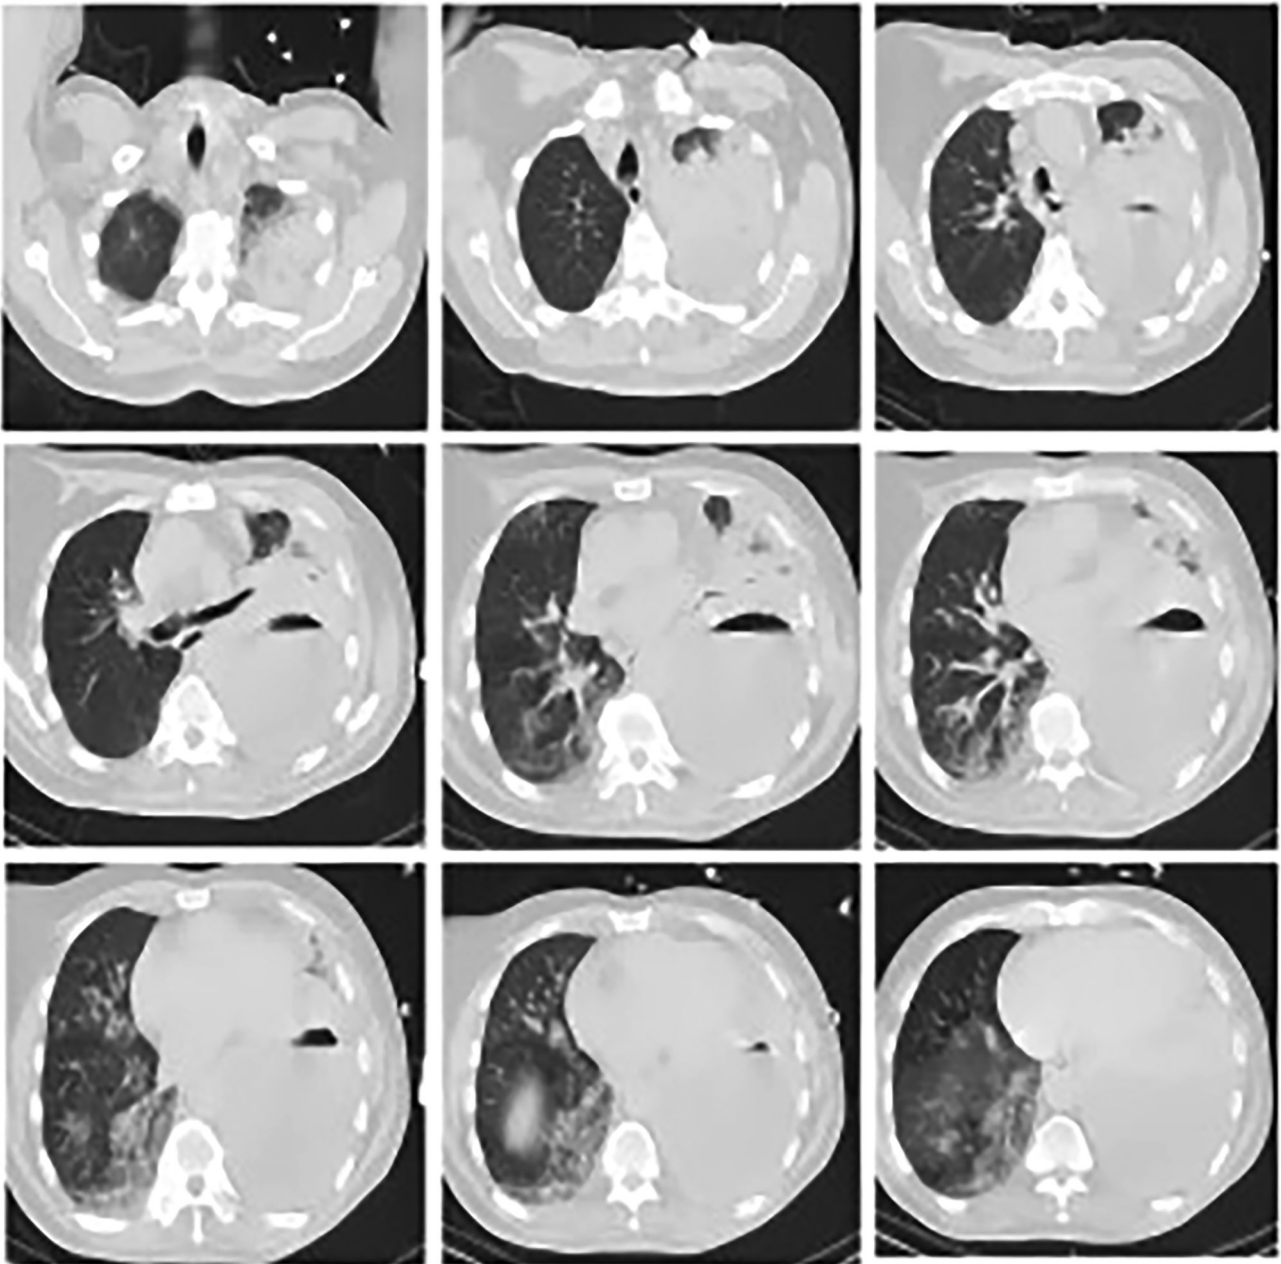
Chest computed tomography images of the patient on admission showing a large left pleural effusion, left lung consolidation, and right lower lung infection.
